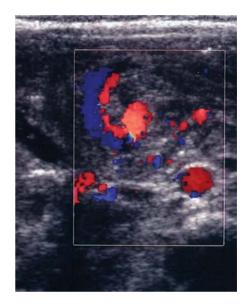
An infant with intestinal malrotation. Note the abnormal position and course of the superior mesenteric artery and vein imaged by color Doppler sonogram (the "whirlpool sign")
